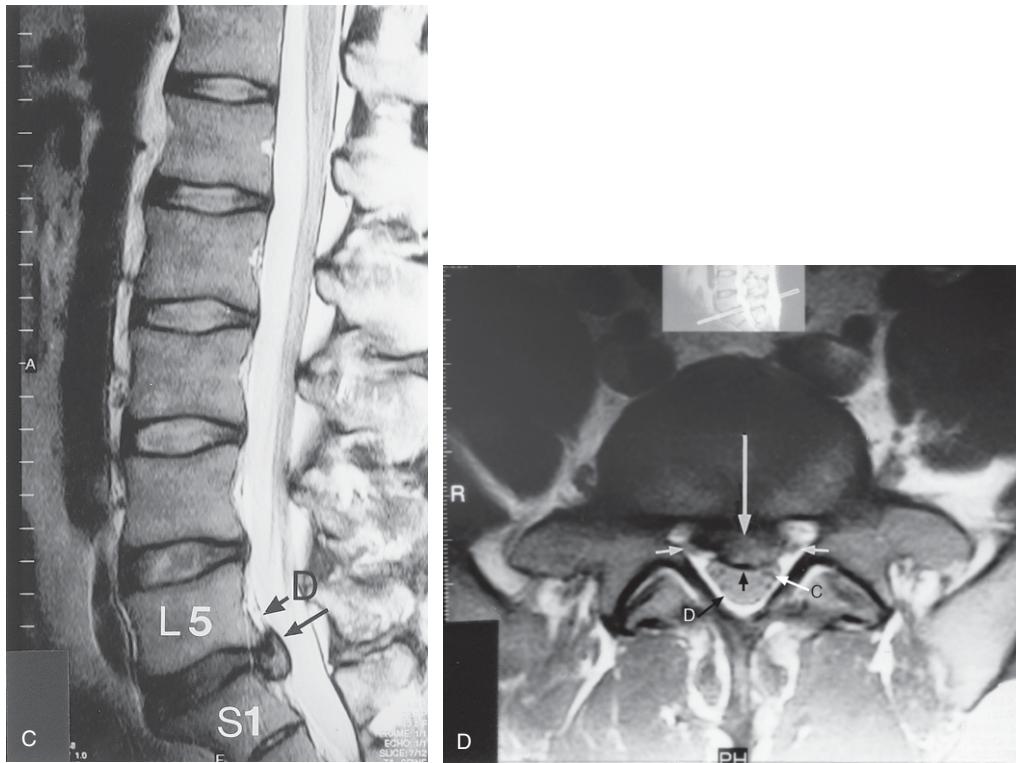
Cont'd (C) Lumbosacral spine MRI sagittal T2-weighted image showing the S1 = first sacral segment. The posterior disc protrusion at the L5–S1 level is shown by the black arrow; it can be seen compressing the anterior part of the dural tube (D). Note that the disc is becoming 'black' between L5 and S1 which indicates that it is undergoing dehydration (desiccation) as a result of injury. The L4–5 disc shows some early desiccation with essentially normal disc hydration at the levels above. (D) Lumbosacral MRI axial T2-weighted image at the L5–S1 level. The long arrow shows the degree of disc protrusion and the effect that it is having on the pain sensitive anterior surface of the dural tube (D) (small black arrow) and, to some extent, on the S1 nerve roots (small white arrows). C = cauda equina nerve roots; R = right side of patient.
